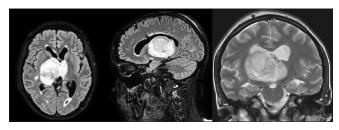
Brain magnetic resonance imaging preoperative showing a large right thalamic lesion.
